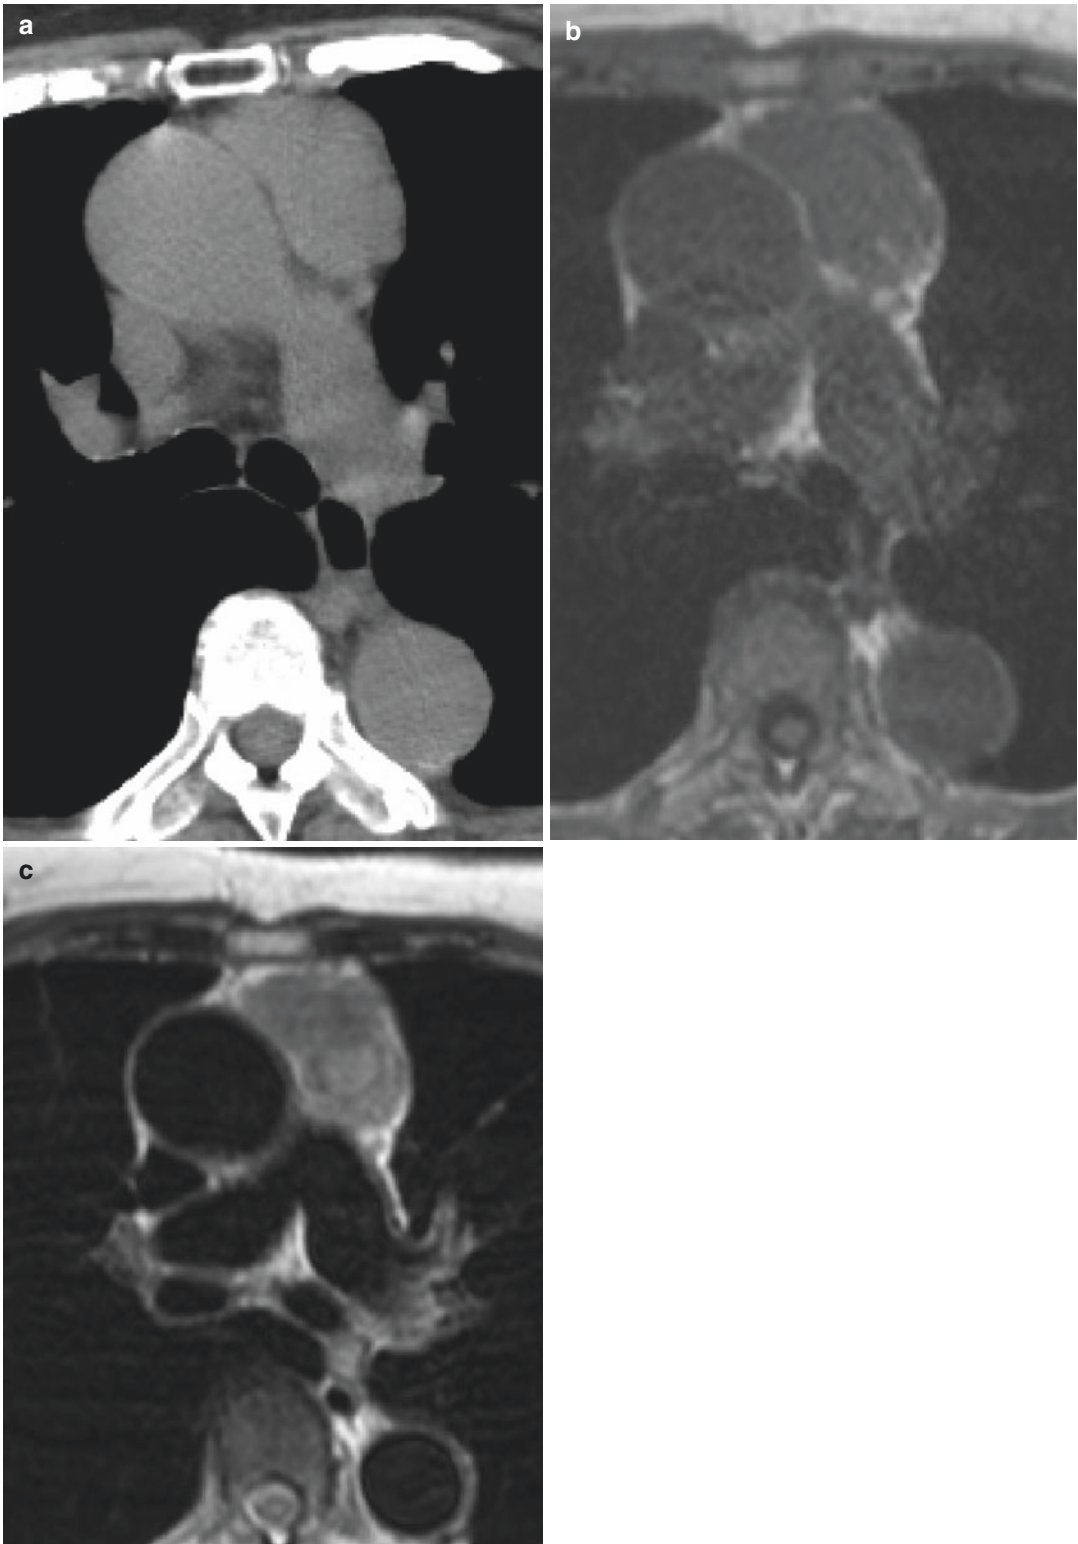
Invasive thymoma. (a) Non-contrast-enhanced CT, (b) T1-weighted, and (c) T2-weighted MR images show an irregular mass with inhomogeneous intensity on T2-weighted image
